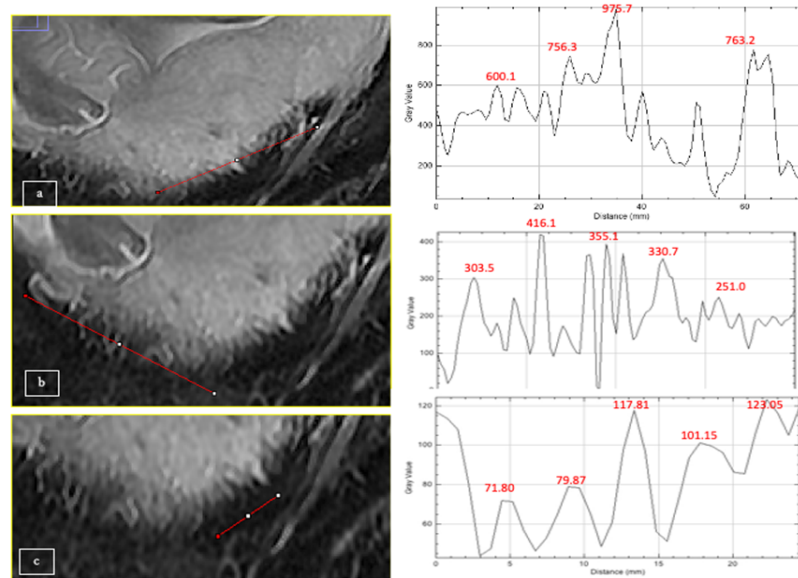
The myometrium at the placental attachment around the bladder was divided into three layers (a: the upper layer of myometrium, b: the middle layer of myometrium. c: the deep layer of myometrium). Image analysis: The graph depicts gray value of each MR image. A peak grayscale value coincided with the high signal of either invasion or vasculature within the myometrium on MRI-T2 weighted imaging.
